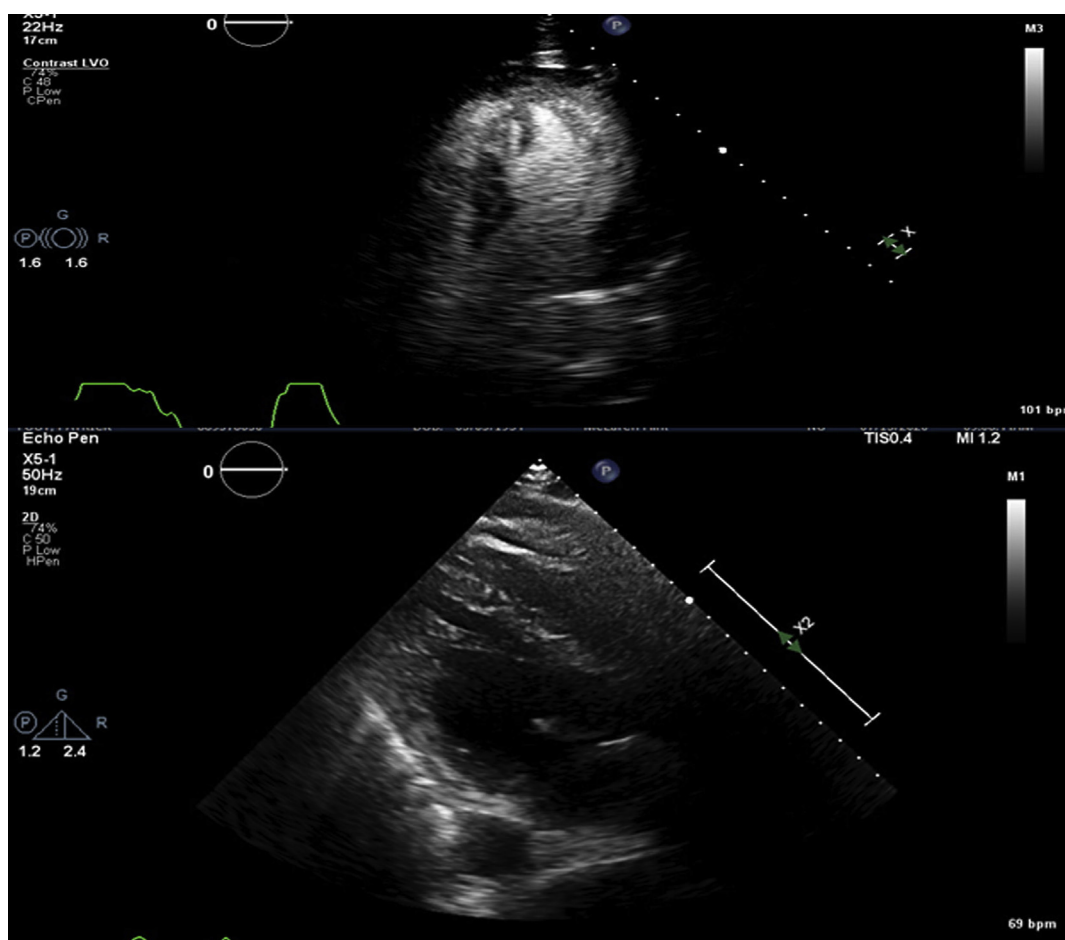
Transthoracic echocardiogram showed an LVEF of 40–45% and the thick muscular bands in the left ventricle. A contrast agent was used to improve the endocardial definition. The Superior image shows contrast opacification of LV.
